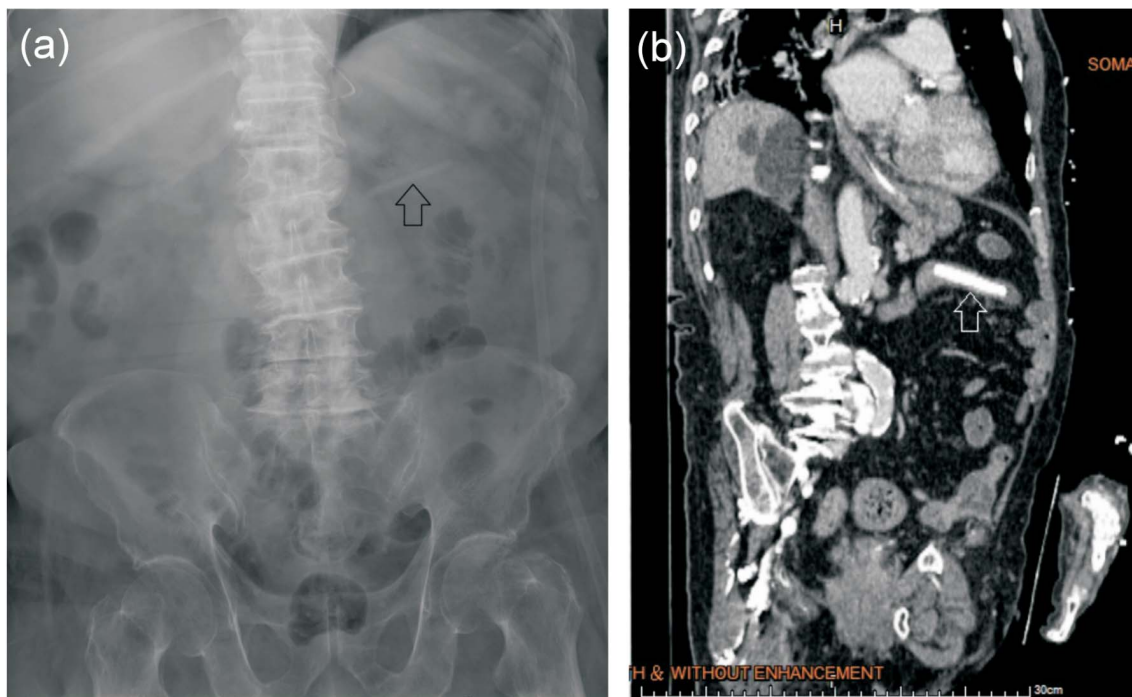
(a) Abdominal X-ray revealed a rod-shaped foreign body measuring approximately 5 cm in length located in the left upper abdomen. (b) Subsequent abdominal computed tomography (CT) imaging demonstrated a 5.4 centimeter, rodshaped lesion within the proximal jejunum.
